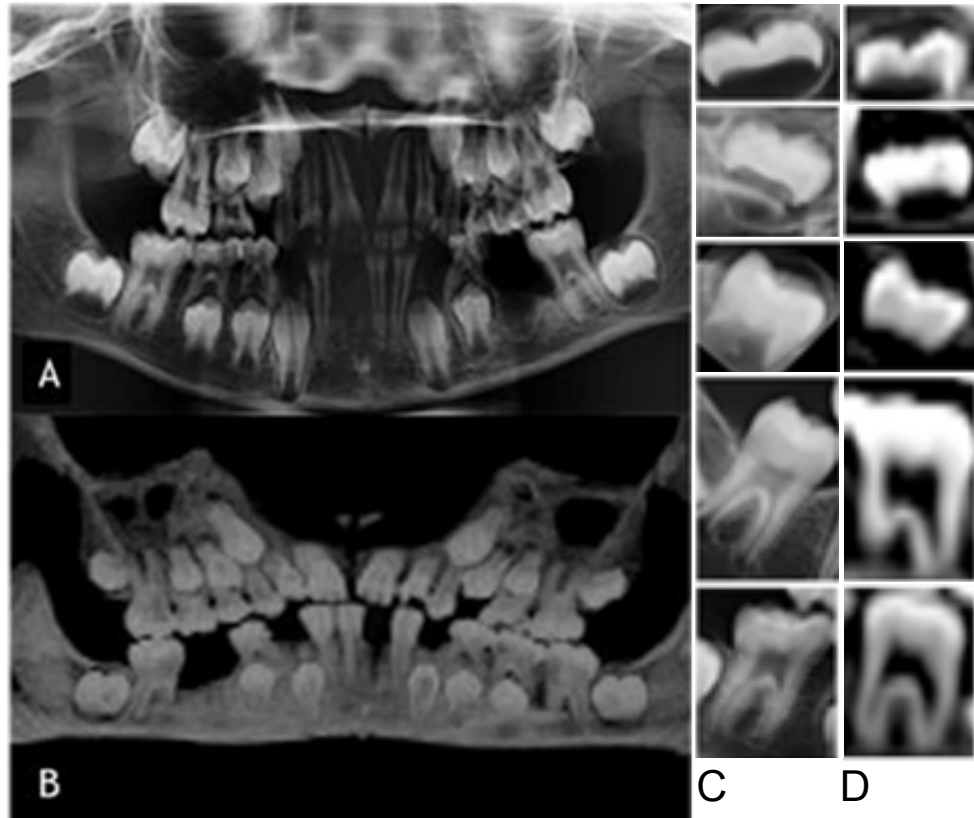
Orthopantomograph and PMCT curved MPRs. A) Radiographic images traditionally used in Schour and Massler (1937) dental method. B) OsiriX PMCT comparison image C) Radiographic images traditionally used for Demirjian *et al.* (1976) system for dental age assessment. D) OsiriX PMCT comparison images.
